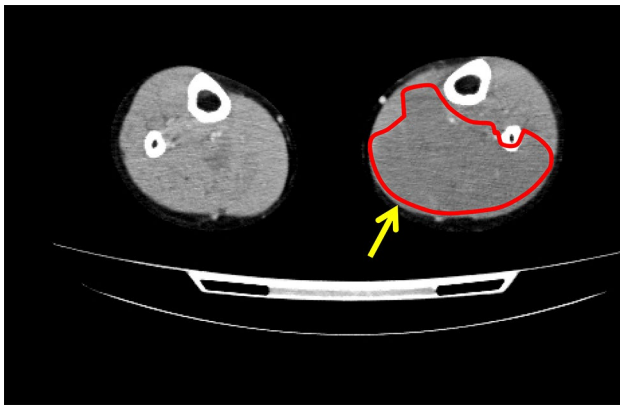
Contrast-enhanced CT image of the lower extremities after surgery in case 1. Inflammatory changes in the soleus muscle and gastrocnemius muscle
